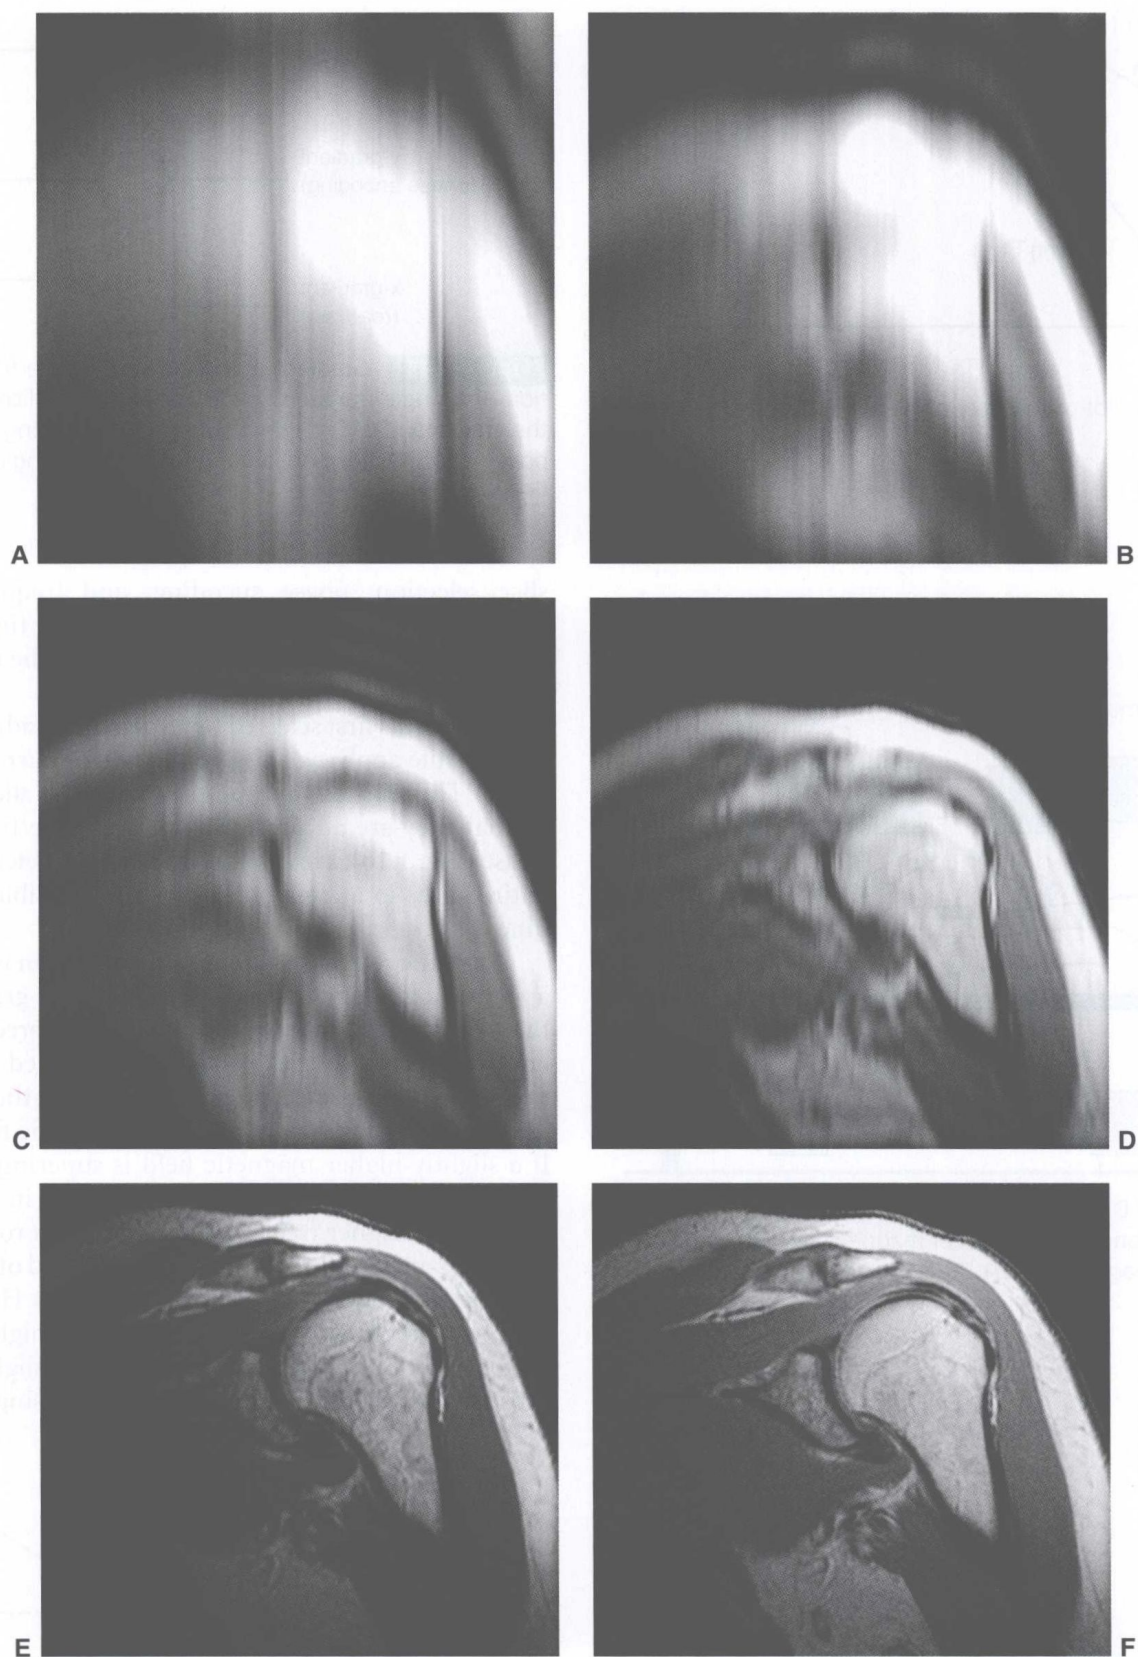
MRI phase encoding (10). All images are from the same acquisition (TR = 500, TE = 20, 2 excitation, 5 mm slice, 256 phase encoding steps). The original raw data were truncated to demonstrate the effect of phase encoding. A: 2 steps. B: 8 steps. C: 16 steps. D: 32 steps. E: 64 steps. F: 256 steps.
